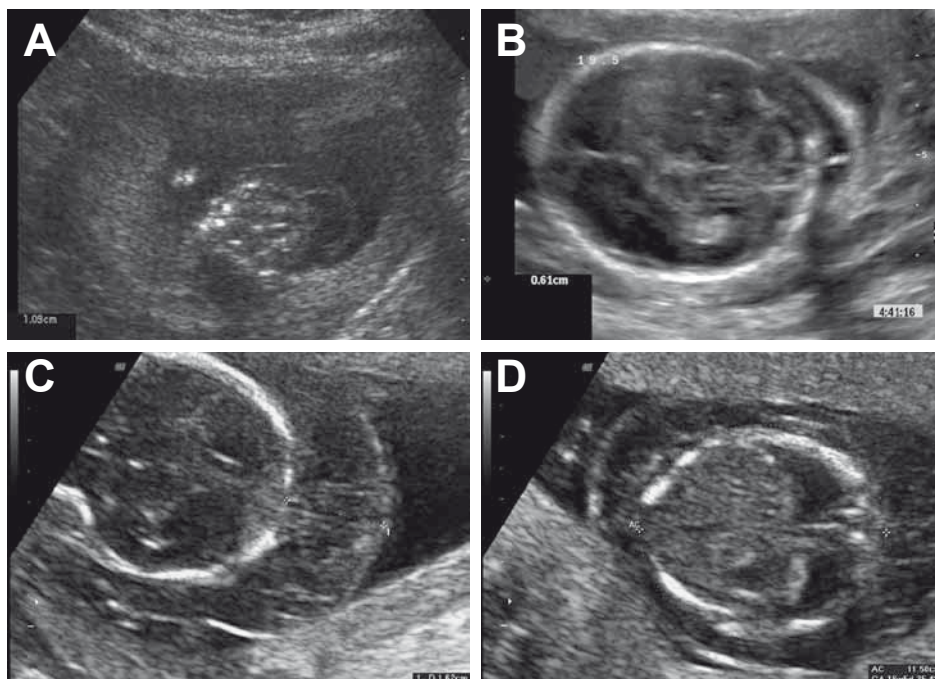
Prenatal ultrasounds performed in (a) patient 2 (II-5) at 14 weeks of gestation showing increased nuchal translucency of 11 mm. (b) patient 3 (II-6) at 19 weeks of gestation showing septated nuchal cystic hygroma of 6 mm. (c) and (d): Patient 4 (II-7) 19 weeks of gestation showing a large nuchal cystic hygroma (c) and bilateral hydrothorax (d).
